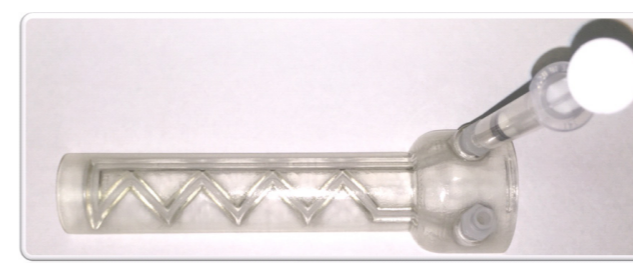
FML with fill syringe installed. The FML inlets are fit with threaded Luers for ease of filling. The line may be filled with mixed contrast agents for MR (water), PET/SPECT (diluted radionuclide), and CT (radiopaque solution).
